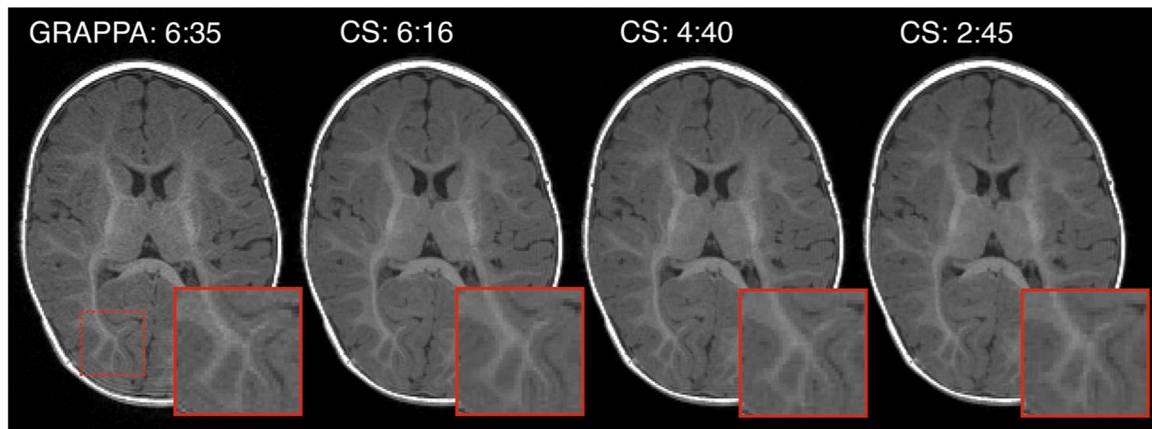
Pilot data, acquired in a 5 month old participant, showing four acceleration factors that were evaluated for T1-weighted protocols during the optimization on the Siemens platform (either GRAPPA or Compressed SENSE, with total scan duration noted). The region outlined by the red dashed box is zoomed for each volume to highlight the effects of acceleration on fine features. Comparing GRAPPA 6:35 to CS 6:15, we can see that compressed sensing of equivalent scan time preserves fine high-contrast structures with less noise than GRAPPA. However, at CS 2:45 the high degree of acceleration leads to a subtle blurring of fine features. Our final protocol set 4 minutes as the target T1-weighted structural scan duration across all three vendors.
